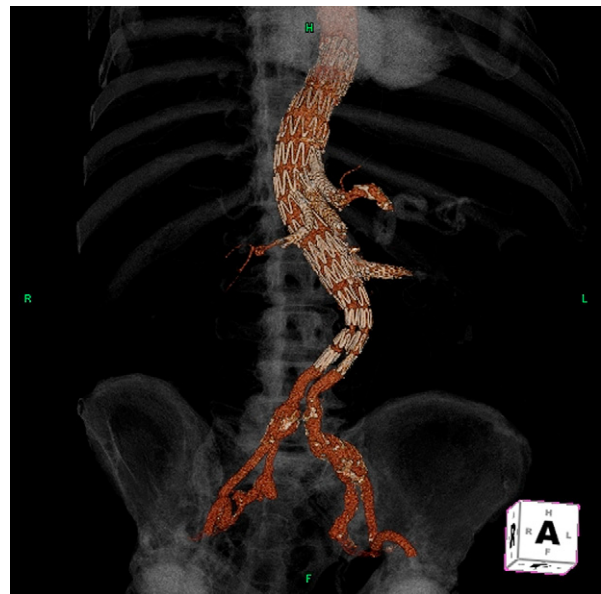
Six-month follow-up CT scan of a four-branched device used to treat a type III TAAA which developed 12 years after aorto-bi-iliac open repair of an infra-renal AAA. In this case the large aortic lumen (10 cm) allowed the use of four caudally oriented branches mated with Fluency grafts (CR Bard, Murray Hill, NJ, USA) to perfuse the visceral vessels.
